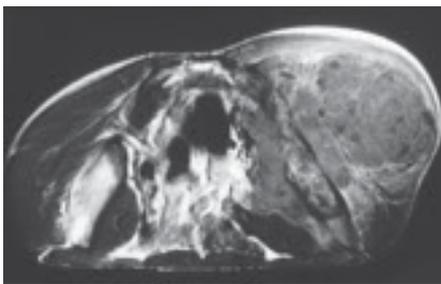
Ewing sarcoma. MRI (T1 image) of pelvic tumour showing a huge soft tissue mass outside and inside the iliac wing.
